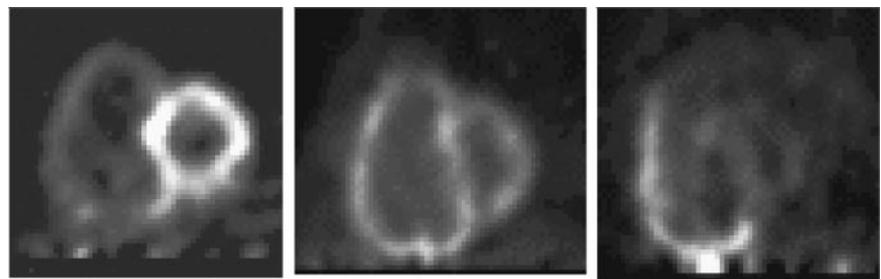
Characteristic short-axis slices from ^{18}F -FDG PET images of 3 patients with different severities of PH. From left to right, images show increasing degree of PAR and decreasing LV metabolic rate of glucose uptake. CO = cardiac output; SW = stroke work; MR = metabolic rate of glucose uptake.
